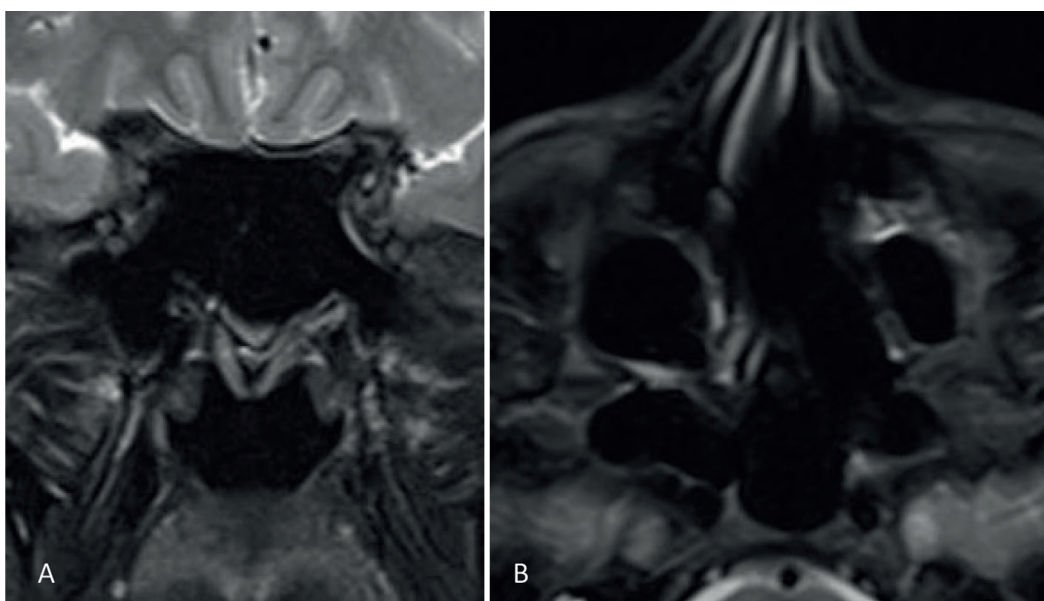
Magnetic resonance imaging, coronal section (A), and axial section (B). No evidence of inverted papilloma recurrence in the sphenoid sinus.
